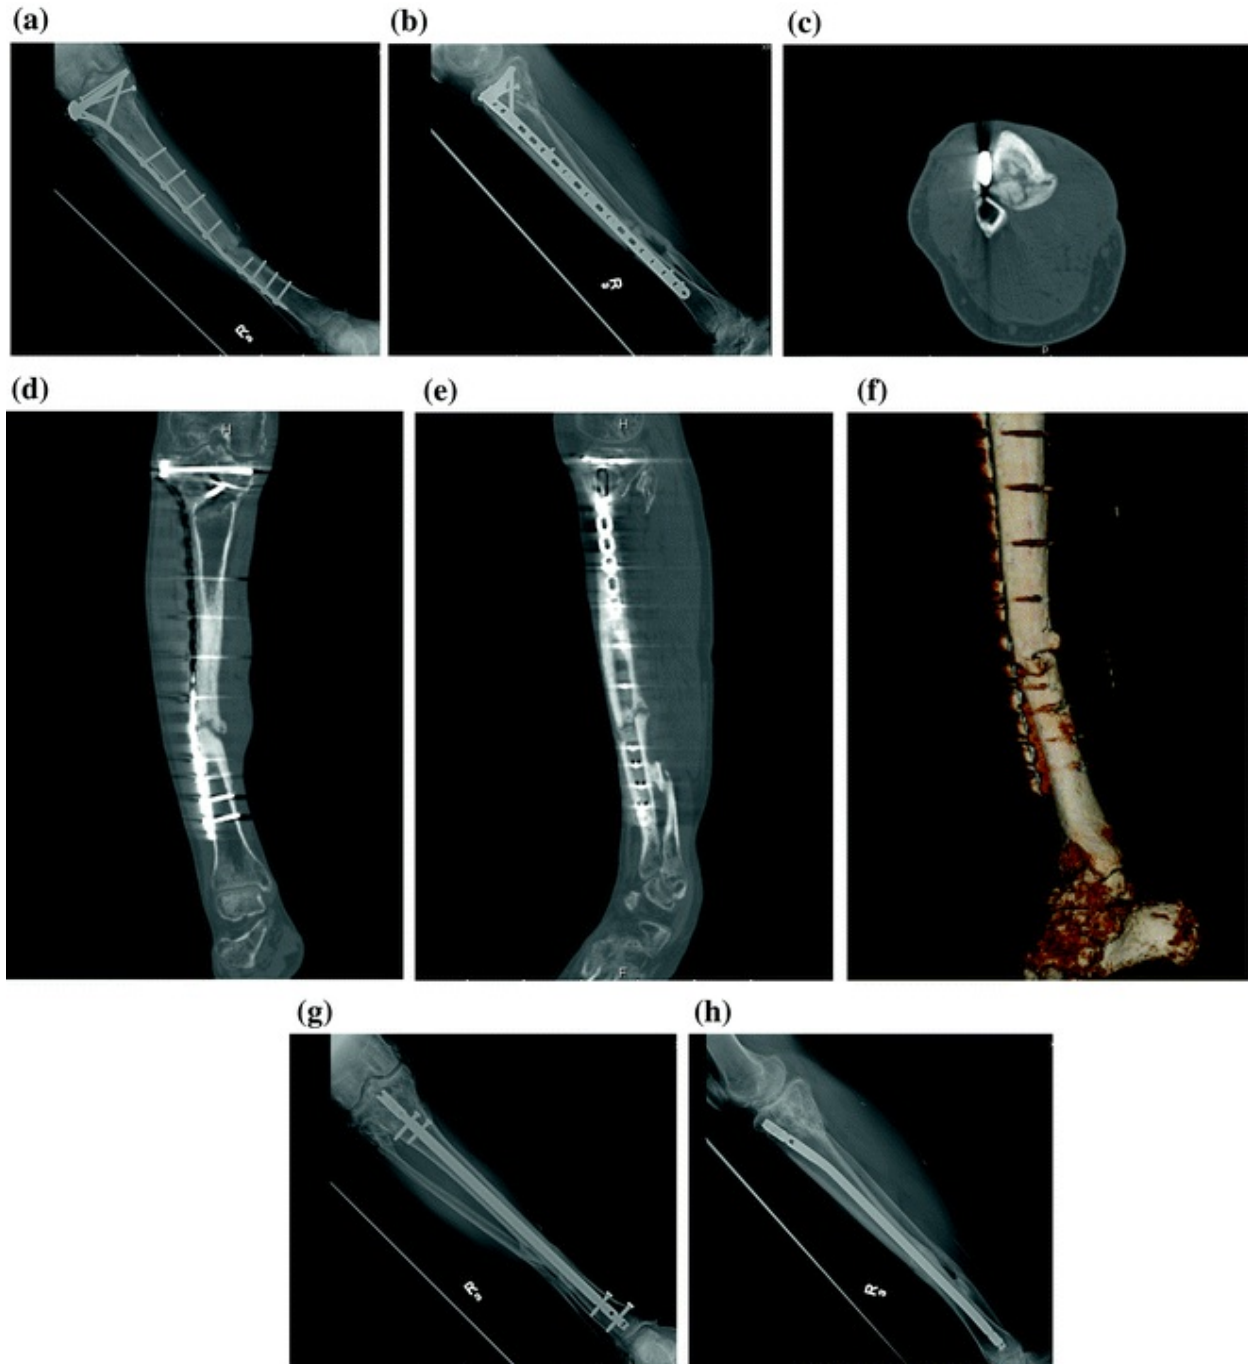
Patient referred for nonunion 9 months after treatment for tibial plateau and tibia shaft fracture treated with open reduction and internal fixation. a, b Anteroposterior (AP) and lateral radiographs of the tibia show consolidation of the plateau component. There is hardware failure and nonunion of the tibial shaft. c–f Computed tomography scan images (axial, coronal, sagittal, and 3D reconstructions) which show the subtle hypertrophic nature of the nonunion. g, h One year after treatment of hypertrophic nonunion with hardware removal and subsequent reamed nailing (AP and lateral)
